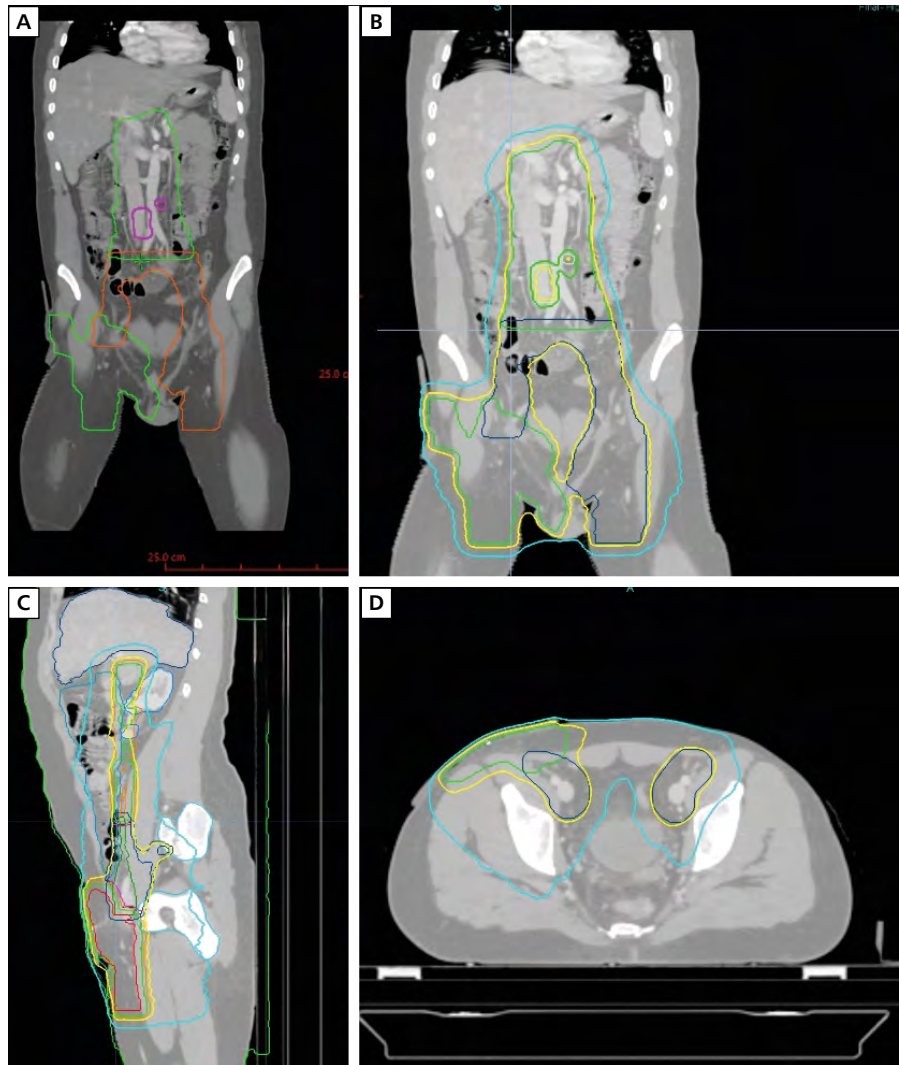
Definitive radiotherapy with simultaneous integrated boosts in an 18-year-old patient with para-testicular spindle cell rhabdomyosarcoma with paraaortic lymph node metastases after right orchidectomy. The figure shows the process of planning computed tomography (A) with delineated target volumes: CTV_51 (orange; left inguinal lymph nodes, bilateral iliac lymph nodes; 51 Gy in 30 fractions), CTV_54 (green; tumor bed, right inguinal lymph nodes and paraaortic lymph nodes; 54 Gy in 30 fractions), CTV_60 (magenta; metastatic paraaortic lymph nodes; 60 Gy in 30 fractions). Other scans (B–D) show different views of the dose distribution. In summary, the patient received 1.7/1.8/2 Gy up to 51/54/60 Gy with concurrent locoregional deep hyperthermia and chemotherapy. After radiotherapy, the patient continued chemotherapy until the end of 2022. After 14 months of follow-up, he remains disease-free
